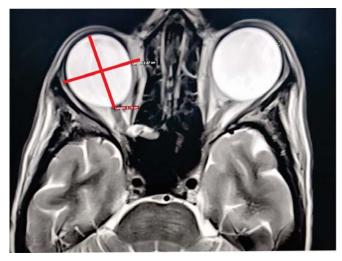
CT suggestive of Bupthalmos in both eyes
